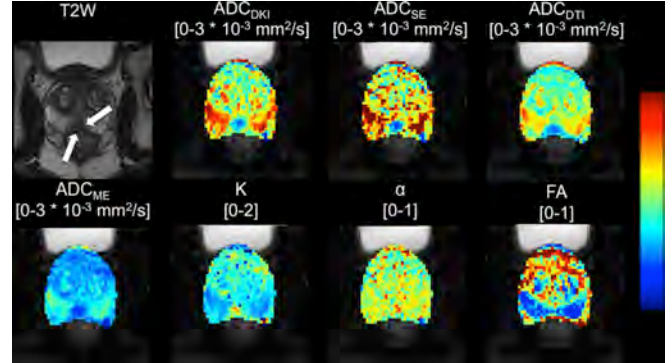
Representative T₂-weighted imaging and DWI parameter maps of a 66 year-old PCa patient with a 12 mm lesion in the right PZ (white arrow on T2W). ADC_{ME} = ADC from monoexponential fit, ADC_{DKI} = ADC from diffusion kurtosis modeling, K = kurtosis parameter from diffusion kurtosis modeling, ADC_{SE} = ADC from stretched-exponential modeling, α = anomalous exponent from stretched-exponential modeling, ADC_{DTI} = ADC from diffusion tensor imaging, FA = fractional anisotropy from diffusion tensor imaging.
